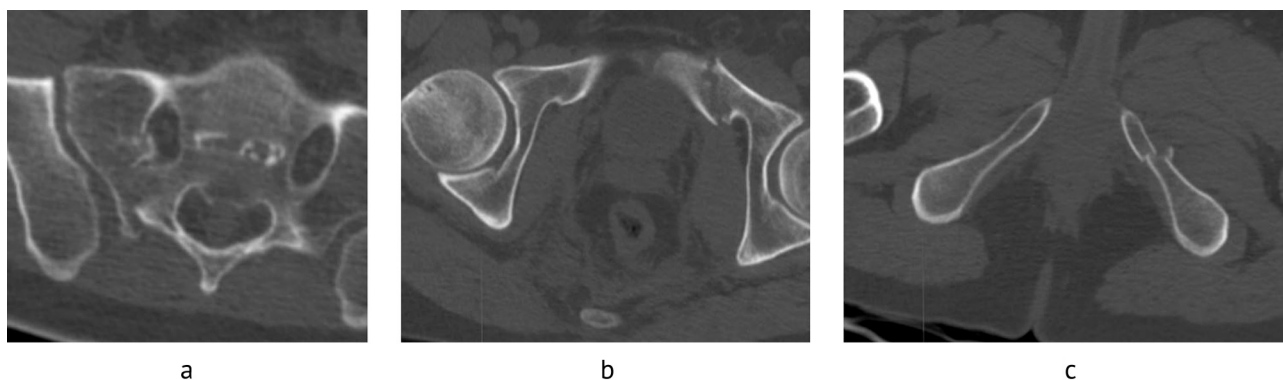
CT sections with visualization: *a* — fracture of the right lateral mass of the sacrum; *b* — fracture of the left pubic bone; *c* — fracture of the left ischium
